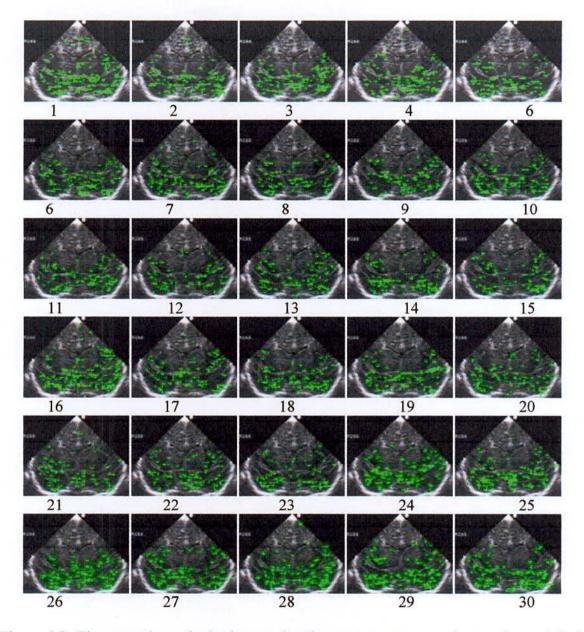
Tissue motion velocity images (motion vectors are super imposed on original ultrasonogram image inside the cranial bone) of 30 frames in anterior coronal section two using Combined local and global Optimization (Baby code: mt22h)
